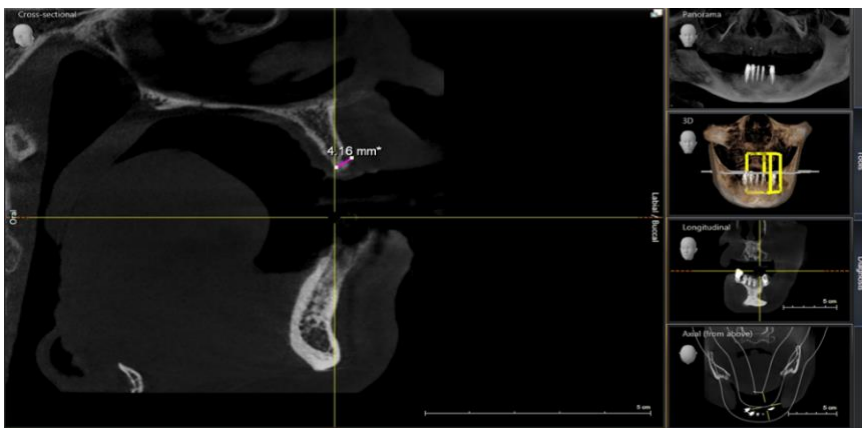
preoperative Cone Beam CT Scan showing the bone thickness on 22.
